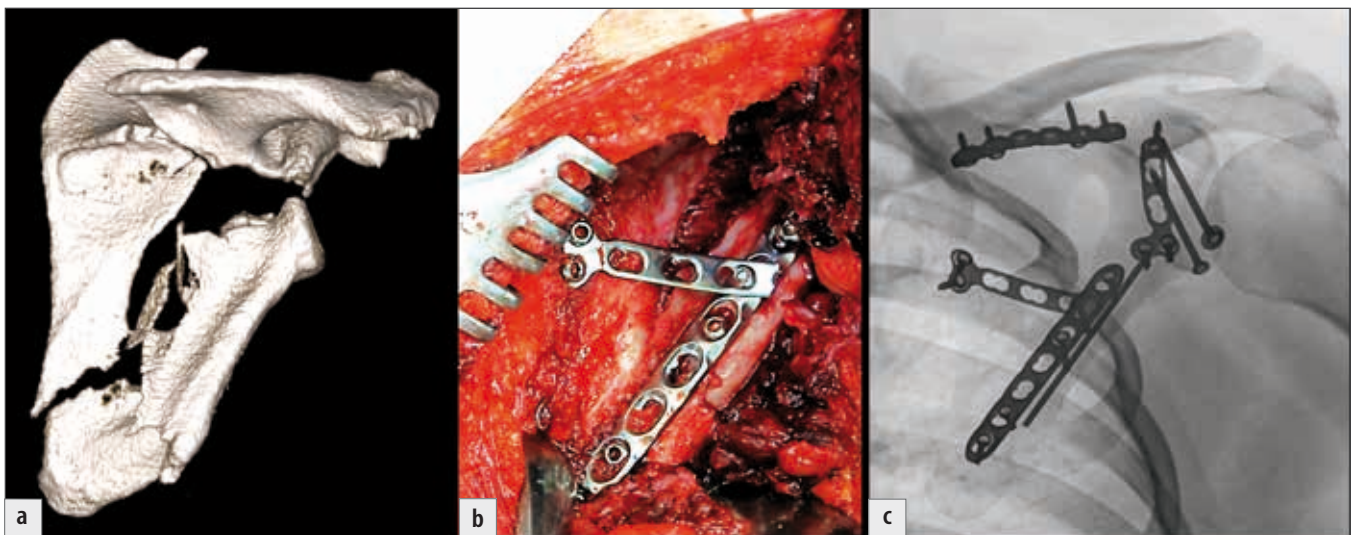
The result of reconstruction: a) preoperative 3D CT reconstruction; b) intraoperative photograph after completion of internal fixation; c) a mirrored postoperative radiograph showing clearly all the implants used, including the K-wire in the lateral pillar.
